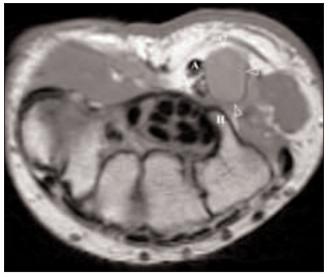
An axial proton density magnetic resonance image from a similar patient demonstrates a ganglion cyst (arrowheads) in Guyon's canal deviating the ulnar nerve (white arrow). A = radial artery, H = hook of hamate.
